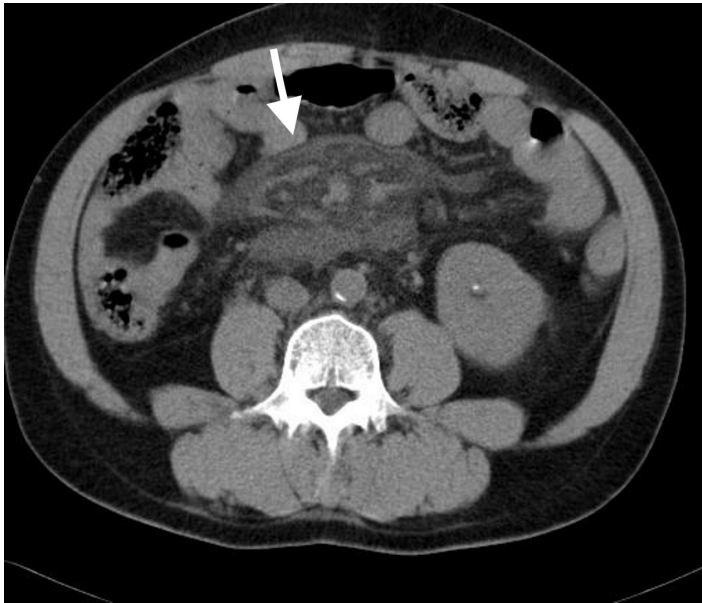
Computed tomography showing “misty mesenteric” vessels surrounded by fat stranding (arrow)
